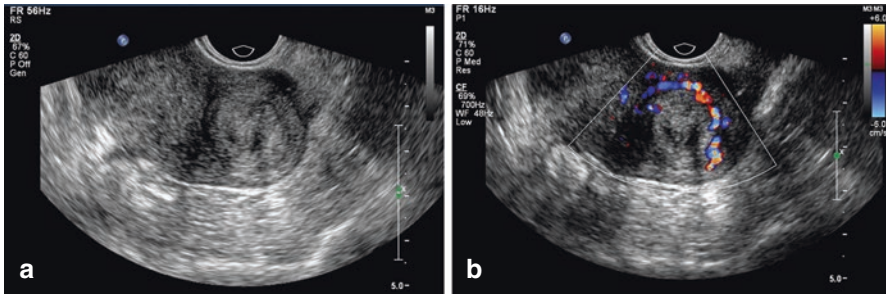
(a and b) TVUS images of uterine fibroids, the uterus is retroverted. (a) is a grey-scale ultrasound image showing the hypoechoic lesion visible at the fundus of the uterus, with regular morphology and clear boundaries; (b) is a CDFI image showing a typical circular blood flow signal around the uterine lesion
